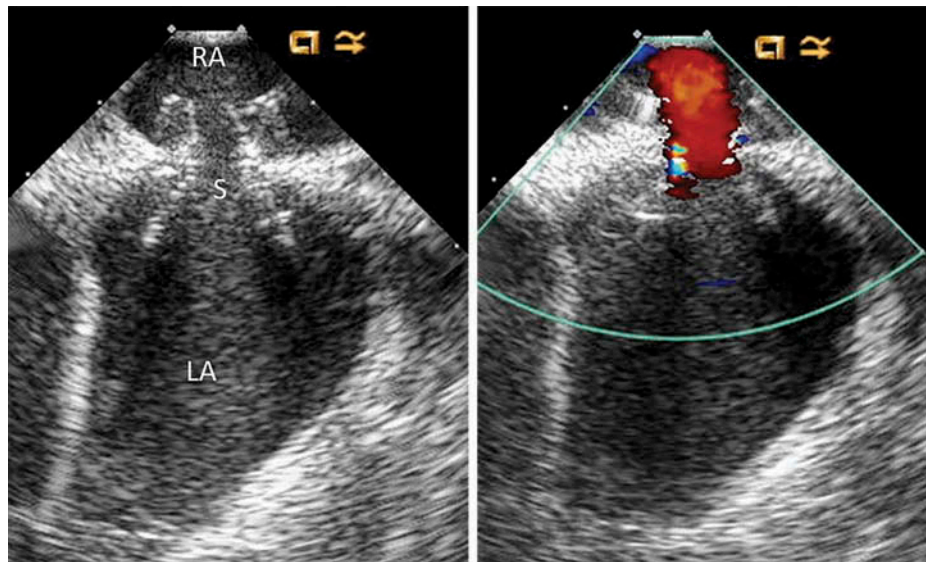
Intracardiac echocardiographic images of tri-leaflet valve shunt at 12-weeks. Left: 2-dimensional scan showing LA, left atrium; RA, right atrium; and S, Shunt device positioned across fossa ovalis. Right: Similar view with color Doppler showing left-to-right flow jet extending into the right atrium demonstrating shunt patency.
